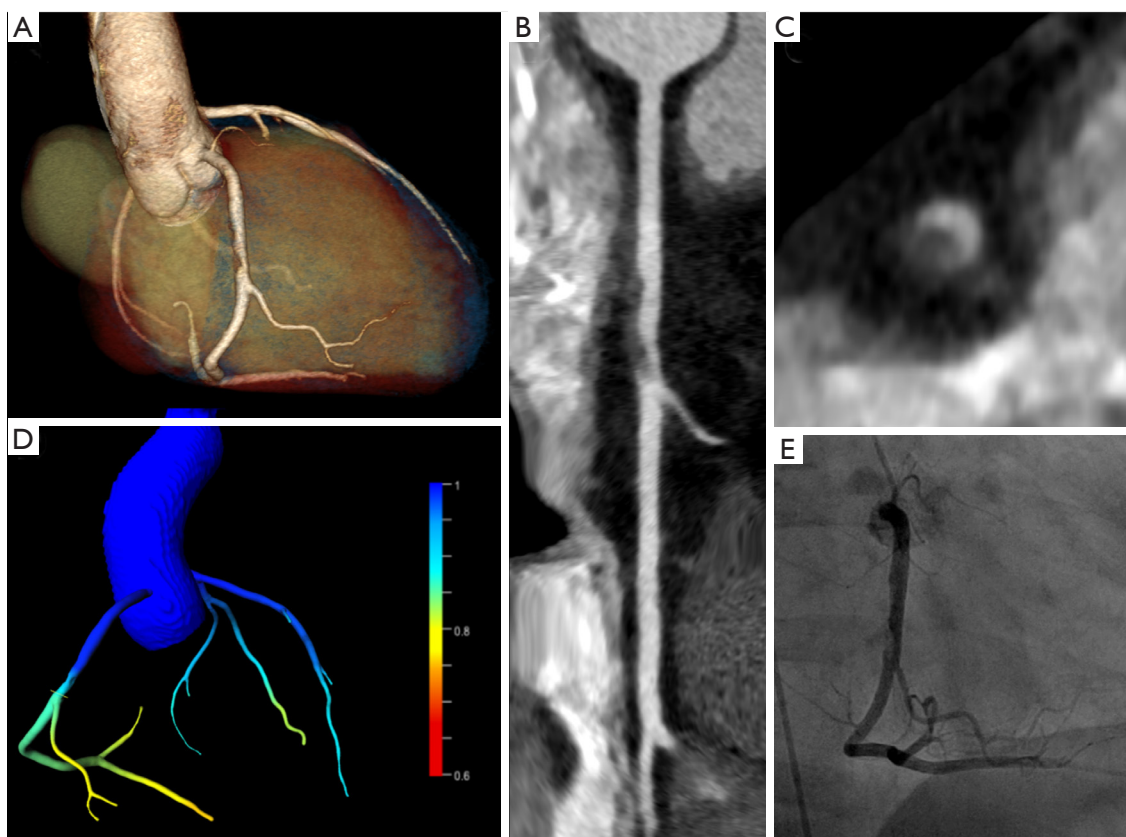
A 32-year-old male patient presenting to the emergency department with acute chest pain, slightly elevated cardiac biomarkers, and a history of pulmonary embolism. After leaving the emergency department against medical advice, the patient returned two days later with persistent symptoms. Cardiovascular risk factors were a positive family history, dyslipidemia, and smoking. The patient refused to undergo invasive coronary angiography (ICA) but agreed on having CT. Chest-pain CT was performed to rule-out recurrent pulmonary embolism and acute coronary syndrome. CT showed hazy intraluminal hypodense material in the mid RCA with positive remodelling, suspicious for acute plaque rupture (A-C). Lesion specific FFR_{CT} was 0.89 (D), which indicates the absence of lesion-specific ischemia. ICA confirmed a thrombus in the mid RCA most probably due to acute plaque rupture (E). Subsequent coronary intervention with stent placement was performed.
